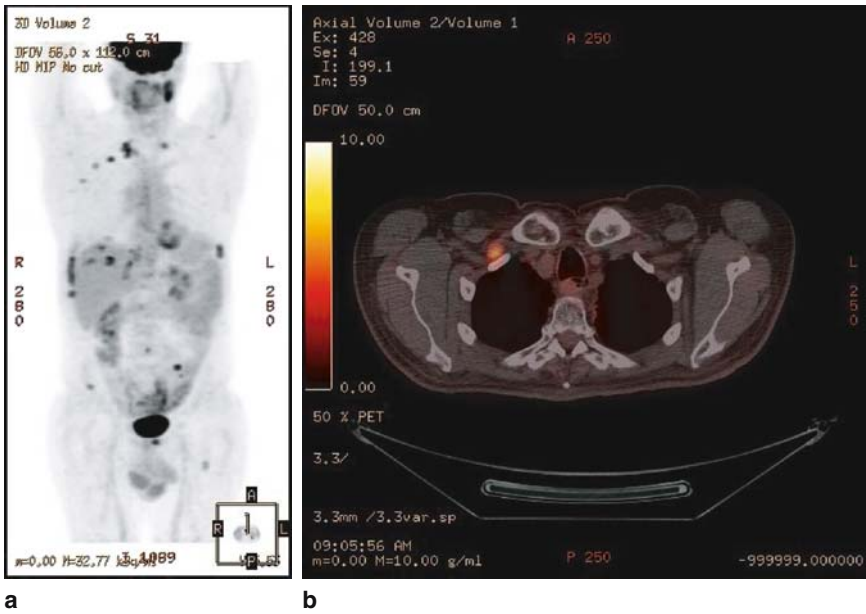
a. PET image of widely metastatic disease to multiple sites above and below the diaphragm. b. PET/CT image of metastatic disease to a left supraclavicular lymph node
